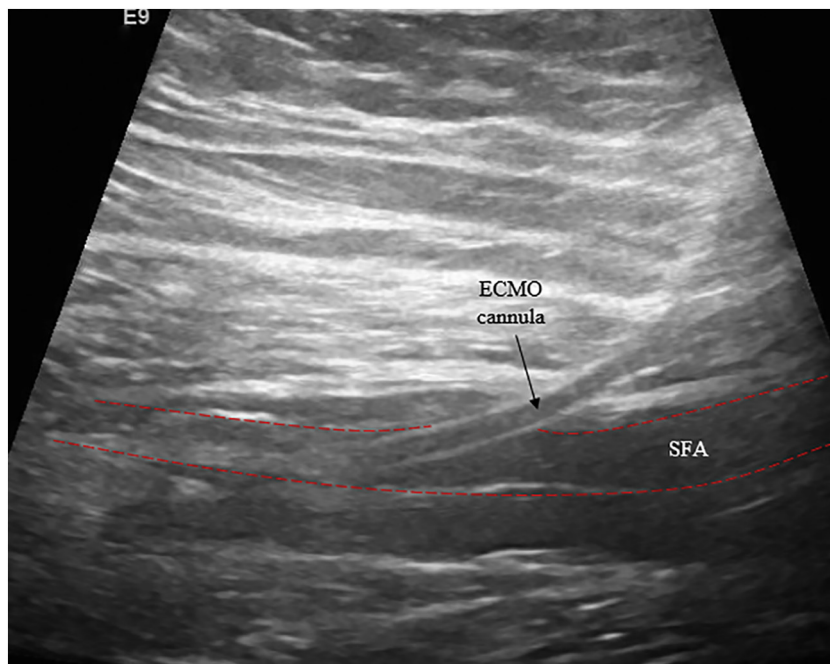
ECMO distal perfusion cannula placement in the superficial femoral artery under ultrasound guidance. SFA- Superficial femoral artery.
